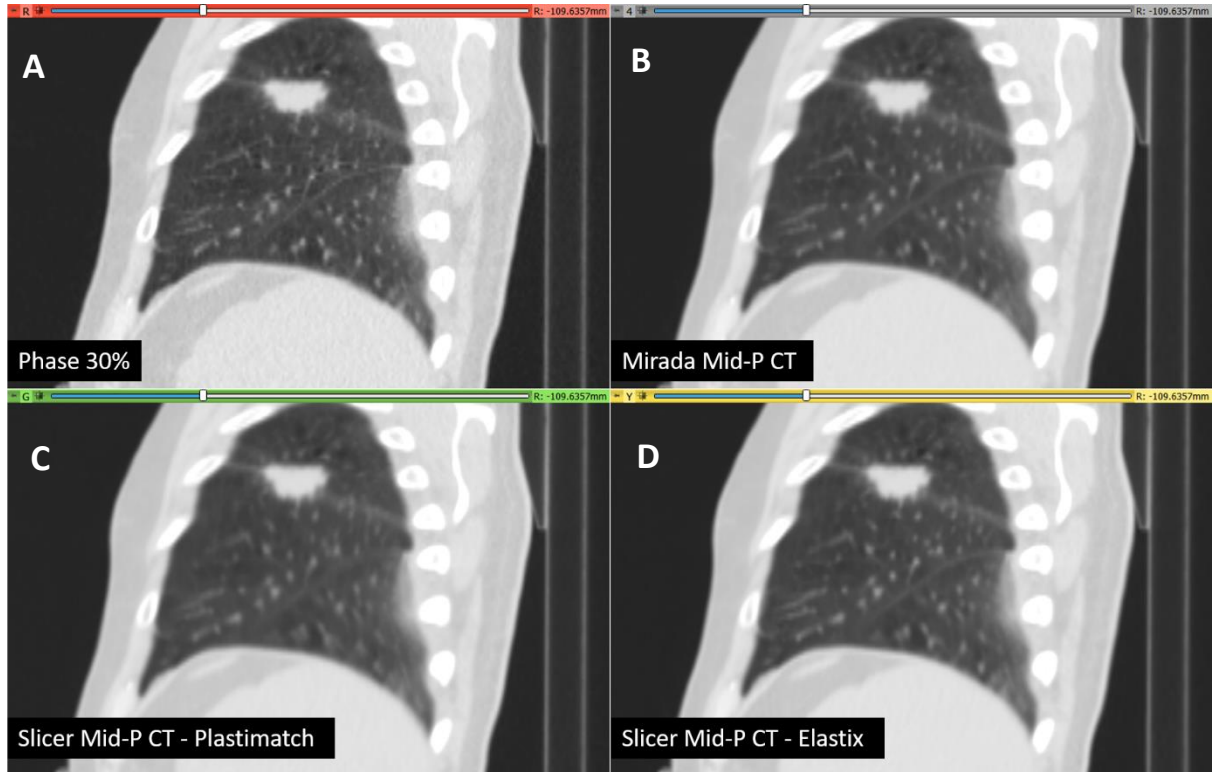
Comparison between (A) one frame of the 4DCT (phase 30%); (B) the Mid-P CT reconstructed by Mirada Medical software; (C) the Mid-P CT reconstructed by 3D Slicer with Plastimatch registration software; and (D) the Mid-P CT reconstructed by Elastix registration software.
